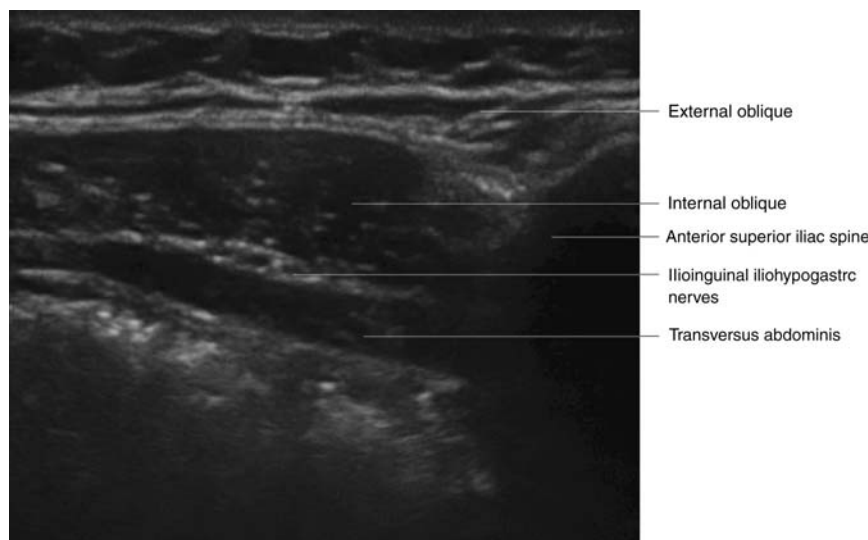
Ultrasound of ilioinguinal and iliohypogastric nerves.
